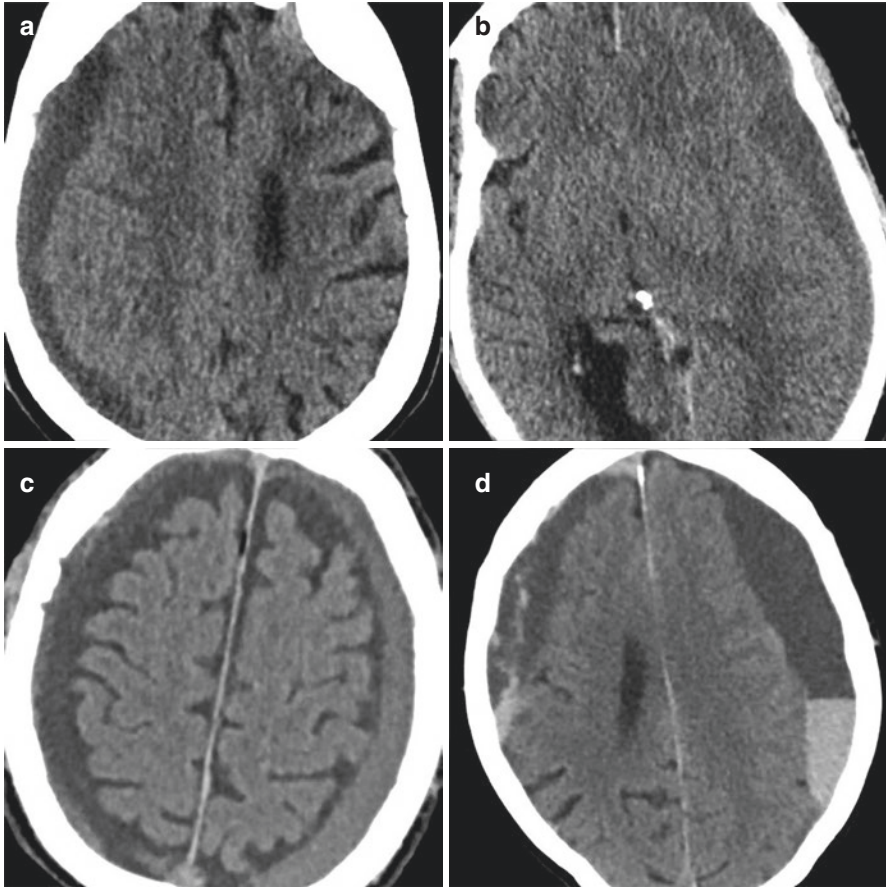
Various hematoma densities seen on brain CT. (a) Low density, (b) iso dense, (c) high density (left convexity), (d) mixed density bilaterally, right convexity loculations
